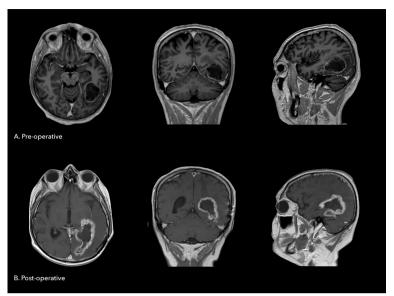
Pre- and post-operative MRI scans for patient FO. Patient FO underwent surgery under general anesthesia for a glioblastoma (IV) in posterior part of the inferior temporal gyrus. A. MRI T1 axial, coronal and sagittal sections obtained 26 days before surgery. B. MRI T1 axial, coronal and sagittal sections obtained 1 year, 3 months after surgery (469 days) with subtotal resection.
